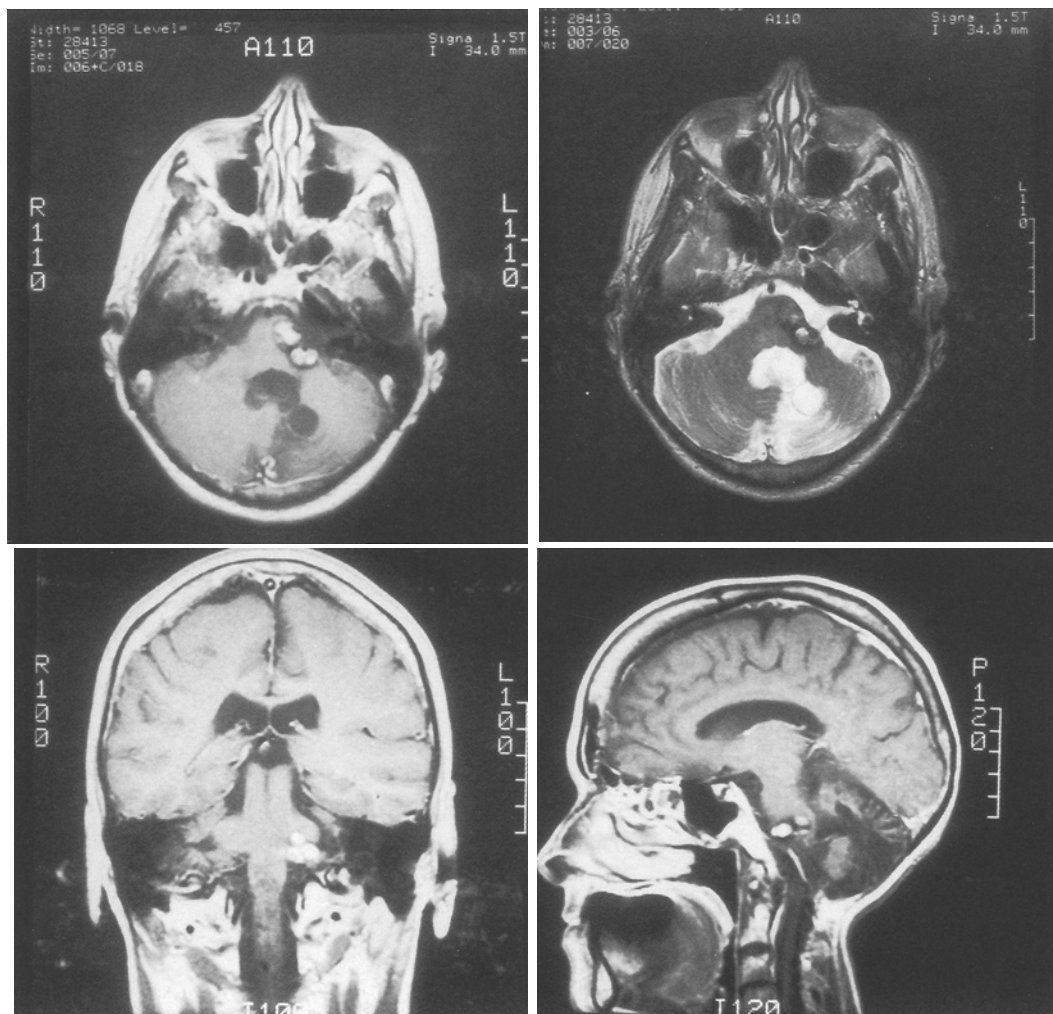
Axial, coronal, and sagittal MRI's showing the characteristic signal change in the pons of cavernous angiomas
